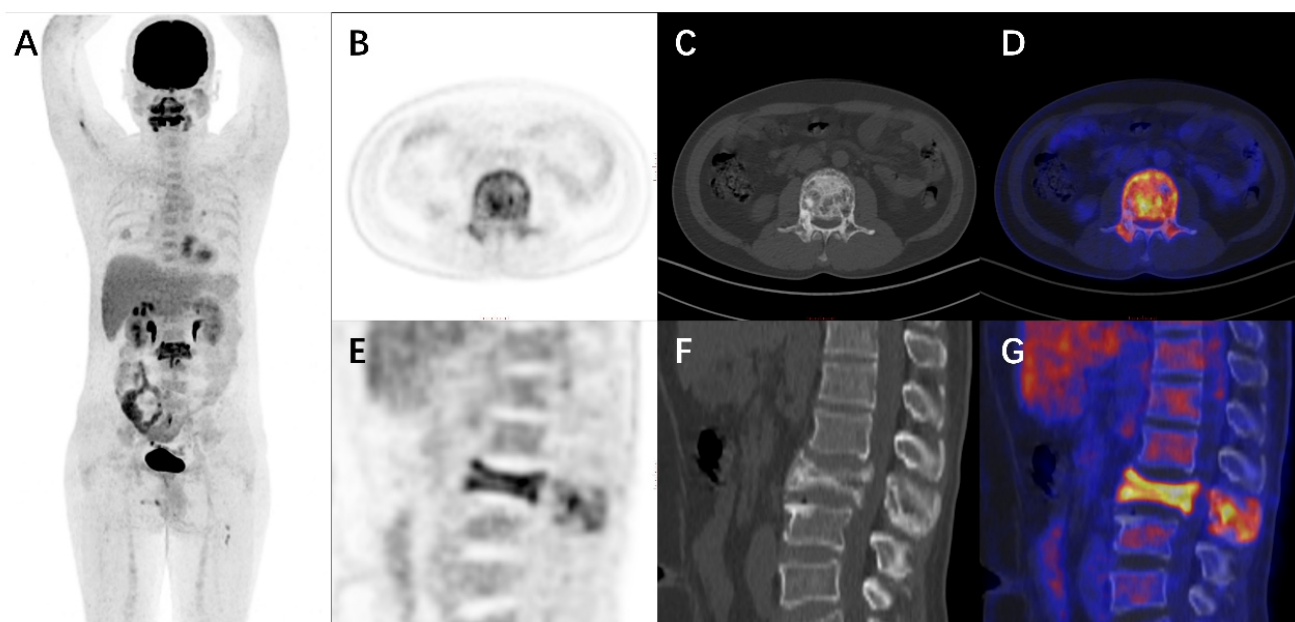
A 46-year-old male patient presented to our hospital with a three-month history of lumbar pain. Abdominal CT revealed flattening of the L2 vertebral body, heterogeneous increased density of the vertebral body and adjacent structures, multiple patchy density shadows within, significant narrowing of the corresponding vertebral canal, and compression of the spinal cord. Suspicion arose regarding a tumorous lesion, prompting further investigation with ¹⁸F-FDG PET/CT for clarification. Maximum intensity projection (MIP) image (A), axial PET (B), CT (C), fusion image (D), and sagittal PET (E), CT (F), fusion image (G) demonstrated compression flattening of the L2 vertebral body, concavity of the upper and lower endplates, increased ¹⁸F-FDG uptake in the L2 vertebral body and its adjacent structures, with a maximum standardized uptake value (SUVmax) of 12.48.
